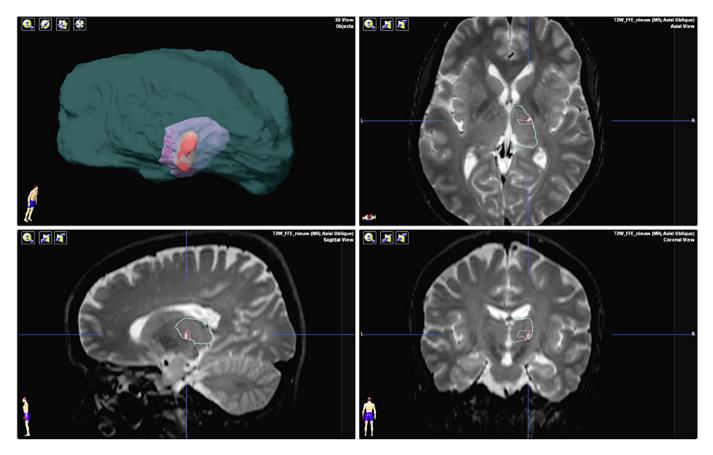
T2-weighted MRI image of the brain of one of the participants. A well-defined hyperintense lesion is visible in the VIM region of the right hemisphere. The right thalamus (blue) and VIM region (pink) are autosegmentated using BrainLab software. Thalamotomy (red) is drawn by hand.
